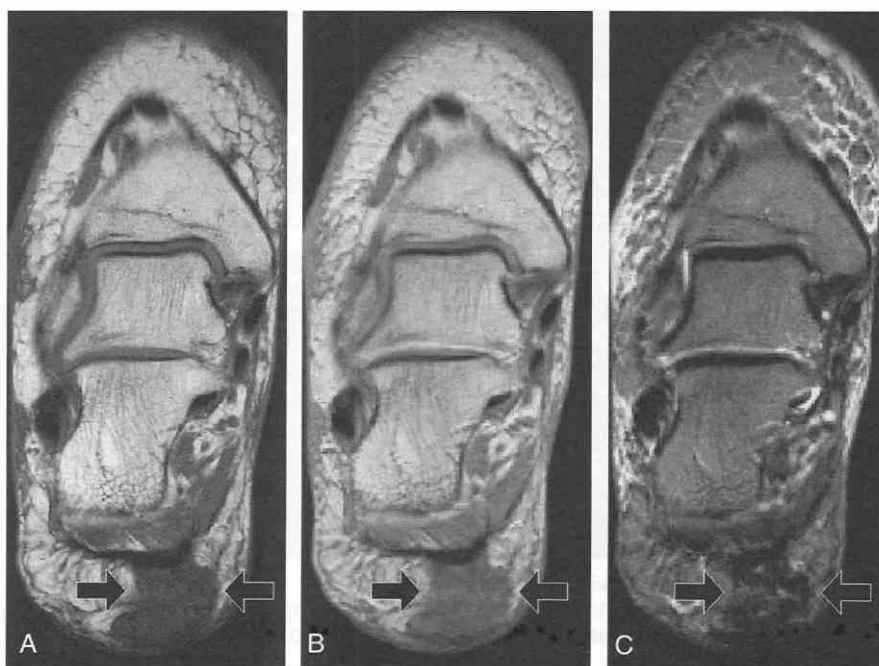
Plantar fibroma in a 44-year-old man. A, Coronal T1-weighted image. B, Coronal proton-density-weighted image. C, Coronal T2-weighted image. The large lesion (*arrows*) is of low signal intensity on all imaging sequences and is confined to the fat of the plantar heel pad.
